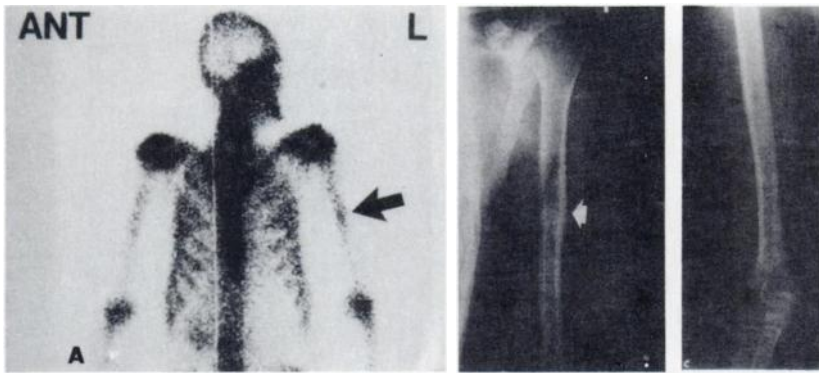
(A) Anterior bone scan demonstrating focal area of increased radionuclide in proximal third of left humerus (arrow). (B) Radiograph of left humerus reveals this area to correspond to prominent deltoid tuberosity. (C) Radiograph of right humerus shows example of a non-thickened cortex at site of insertion of deltoid muscle (arrow).
